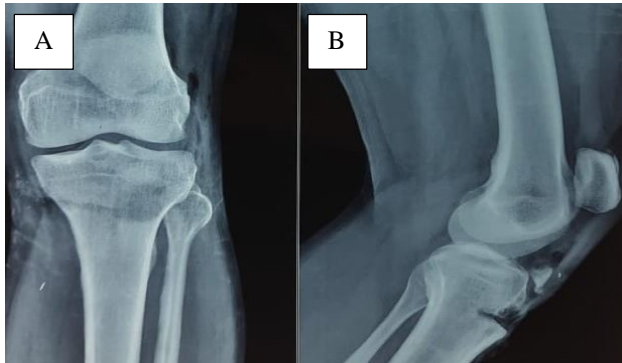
Pre operative A) anteroposterior and B) Lateral radiograph of left knee joint suggestive of tibial tuberosity avulsion.
